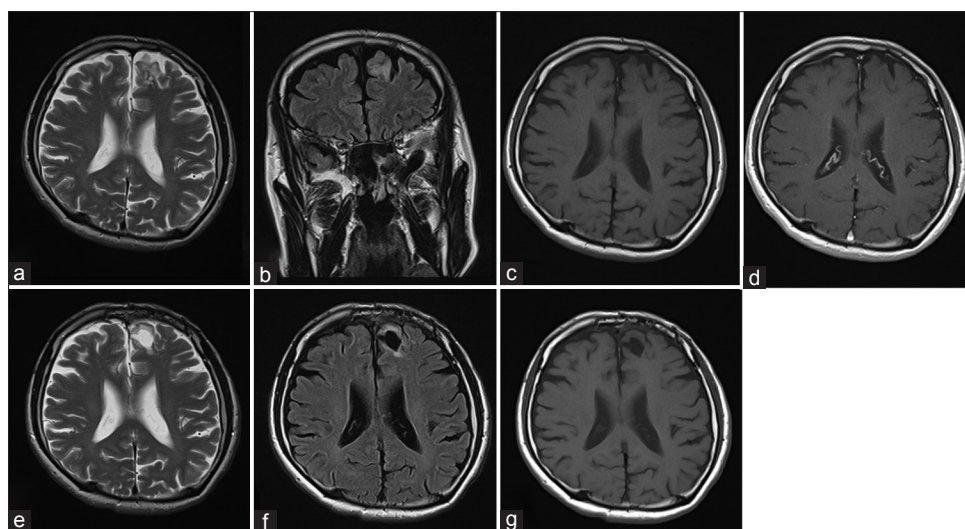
Preoperative MRI revealed the lesion identified in the left superior frontal gyrus (a-d). The lesion showed hyperintensity on T2WI (a) and FLAIR (b). The lesion demonstrated slight hypointensity on T1WI (c) and does not exhibit mass effect, contrast enhancement (d), or associated edema. Postoperative MRI (16 months after operation) showed total resection and the removed cavity with no evidence of tumor recurrence by T2WI (e), FLAIR (f), and T1WI (g).
